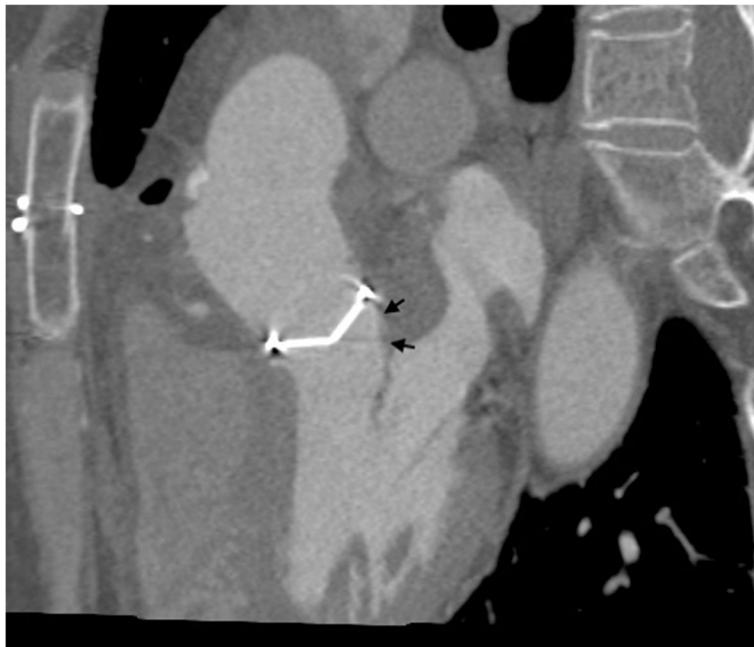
Post-operative computed tomography. The closed entry (arrows) of the pseudoaneurysm of the mitral-aortic intervalvular fibrosa is seen
